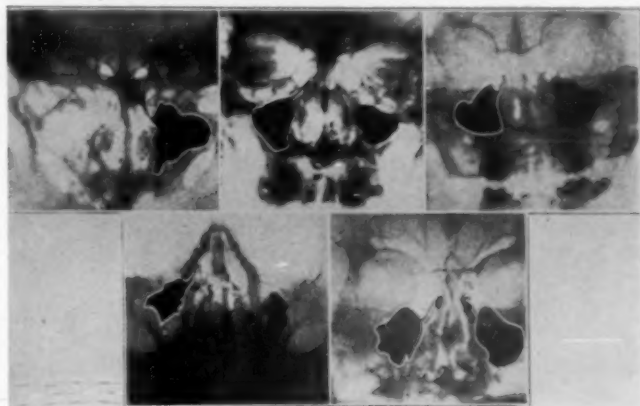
Roentgenographic studies made with iodized oil, showing variety of passageways into maxillary sinus.
